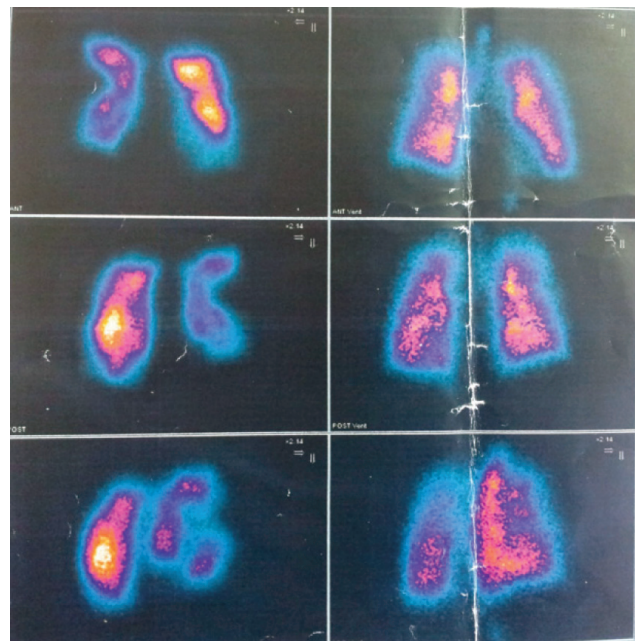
Lung perfusion scan with multiple perfusion defects. CT pulmonary angiography performed at the same time was negative for pulmonary embolism.
